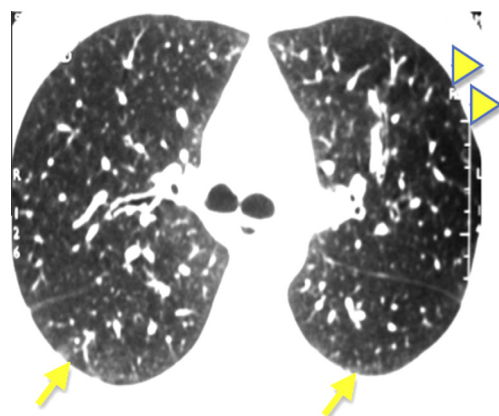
(a,b) A-27-year-old male patient who had an industrial accident; inhaling chlorine. The patient had severe dyspnea and dry cough. HRCT and VB: (a) sagittal minIP image shows the subglottic stenosis and multiple areas of air-trapping (arrow) (b) HRCT images show mosaic perfusion pattern.
